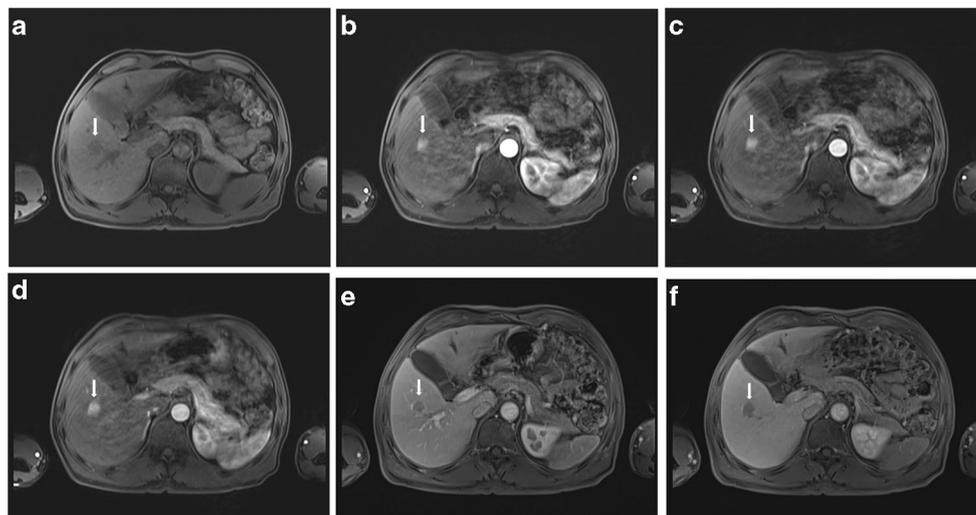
Sixty-year-old man with chronic hepatitis B on gadoteric acid-enhanced liver MR examination using CDT-VIBE sequence with view-sharing. MR images in a pre-contrast, b first arterial, c second arterial, and d third arterial phases, e portal venous phase, and f transitional phase. Note severe motion artifact but interpretable for all arterial phases. MR
